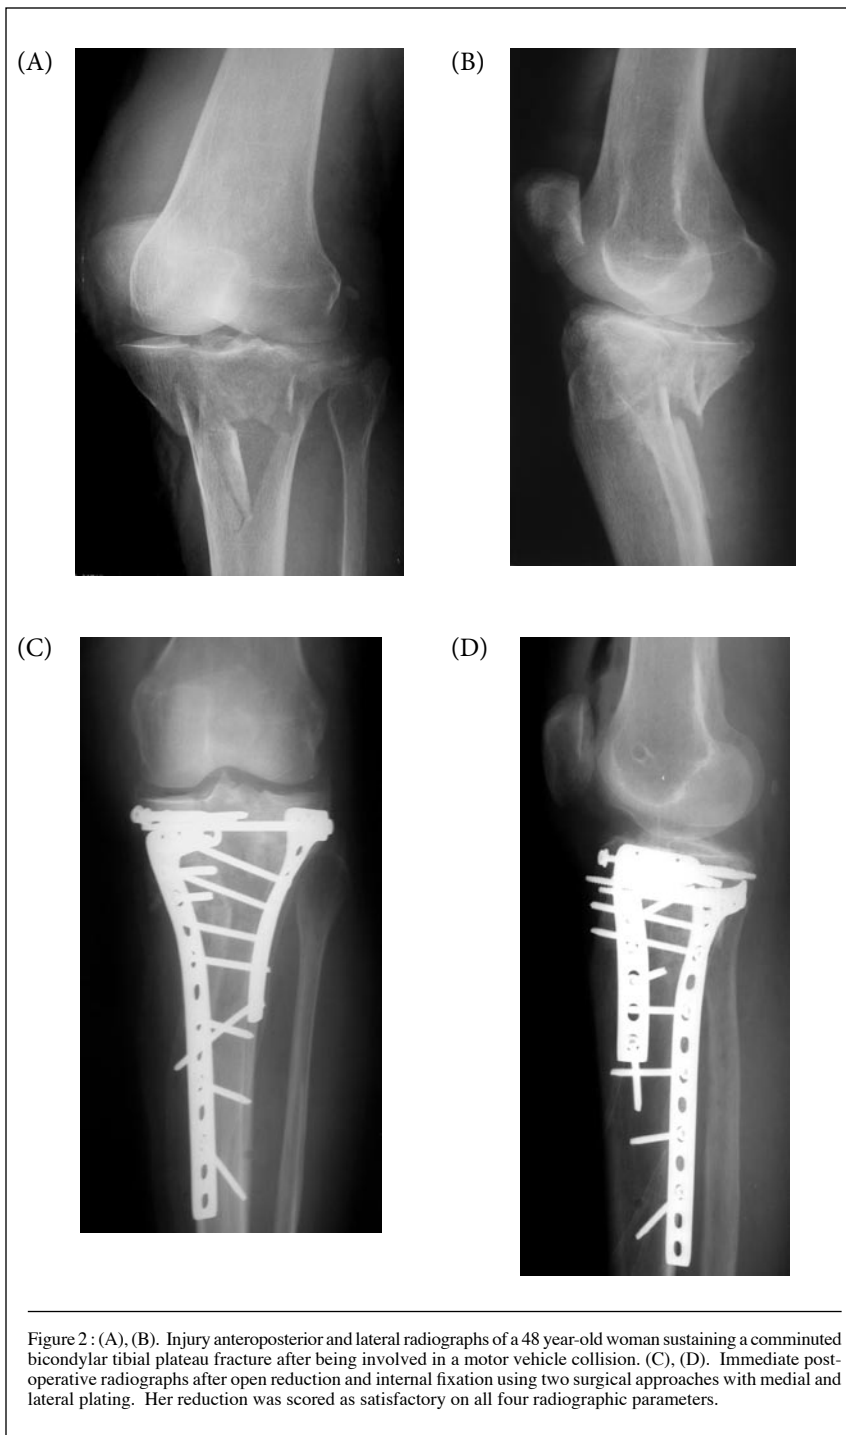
(A), (B). Injury anteroposterior and lateral radiographs of a 48 year-old woman sustaining a comminuted bicondylar tibial plateau fracture after being involved in a motor vehicle collision. (C), (D). Immediate post-operative radiographs after open reduction and internal fixation using two surgical approaches with medial and lateral plating. Her reduction was scored as satisfactory on all four radiographic parameters.
